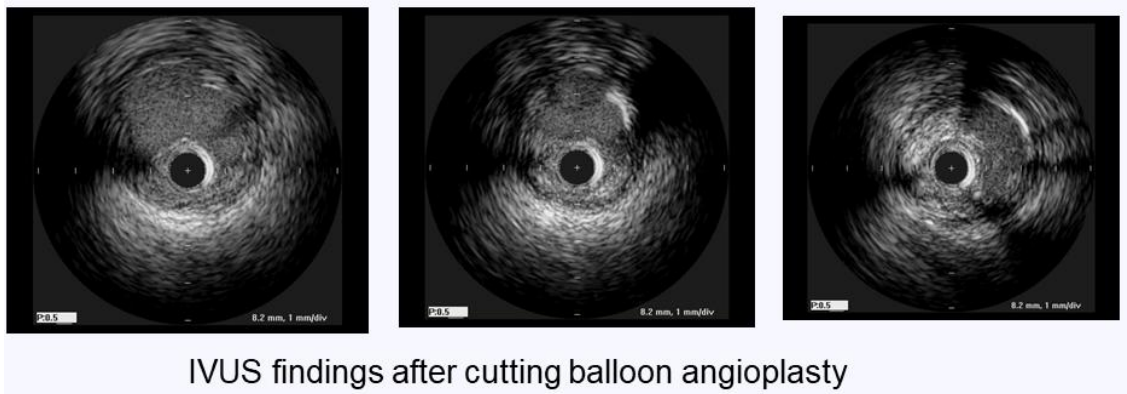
Intravascular ultrasound findings following Cutting balloon™ (Boston Scientific, Marlborough, MA, USA) angioplasty
